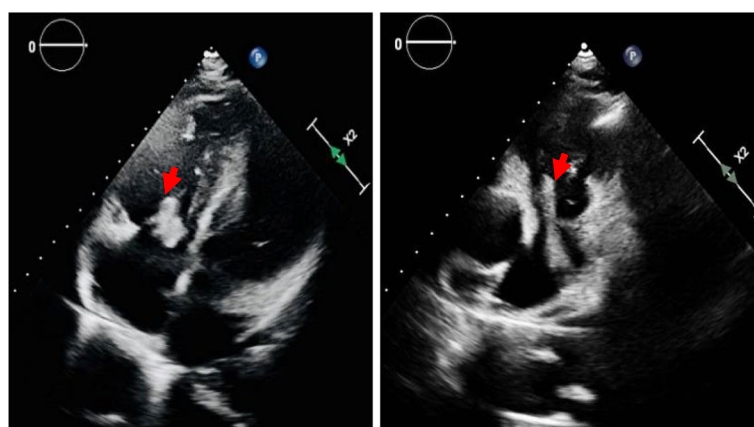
Echocardiography showed the oscillating echogenic mass in right cardiac chambers (A) and pulmonary artery (B) in synchrony with the cardiac cycle
